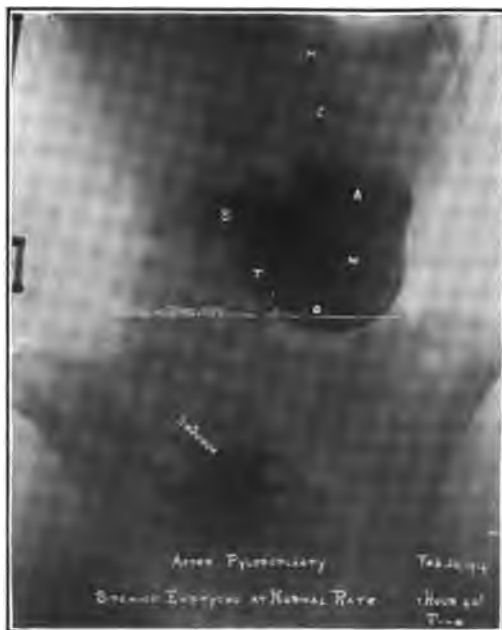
AFTER PYLOROPLASTY FOR PYLOROSPASM. Same case as in fig. 20. Roentgen diagnosis confirmed at operation by Dr. W. A. Downes. No ulcer. Pylorus incised and sutured in transverse direction. Perfect recovery.
